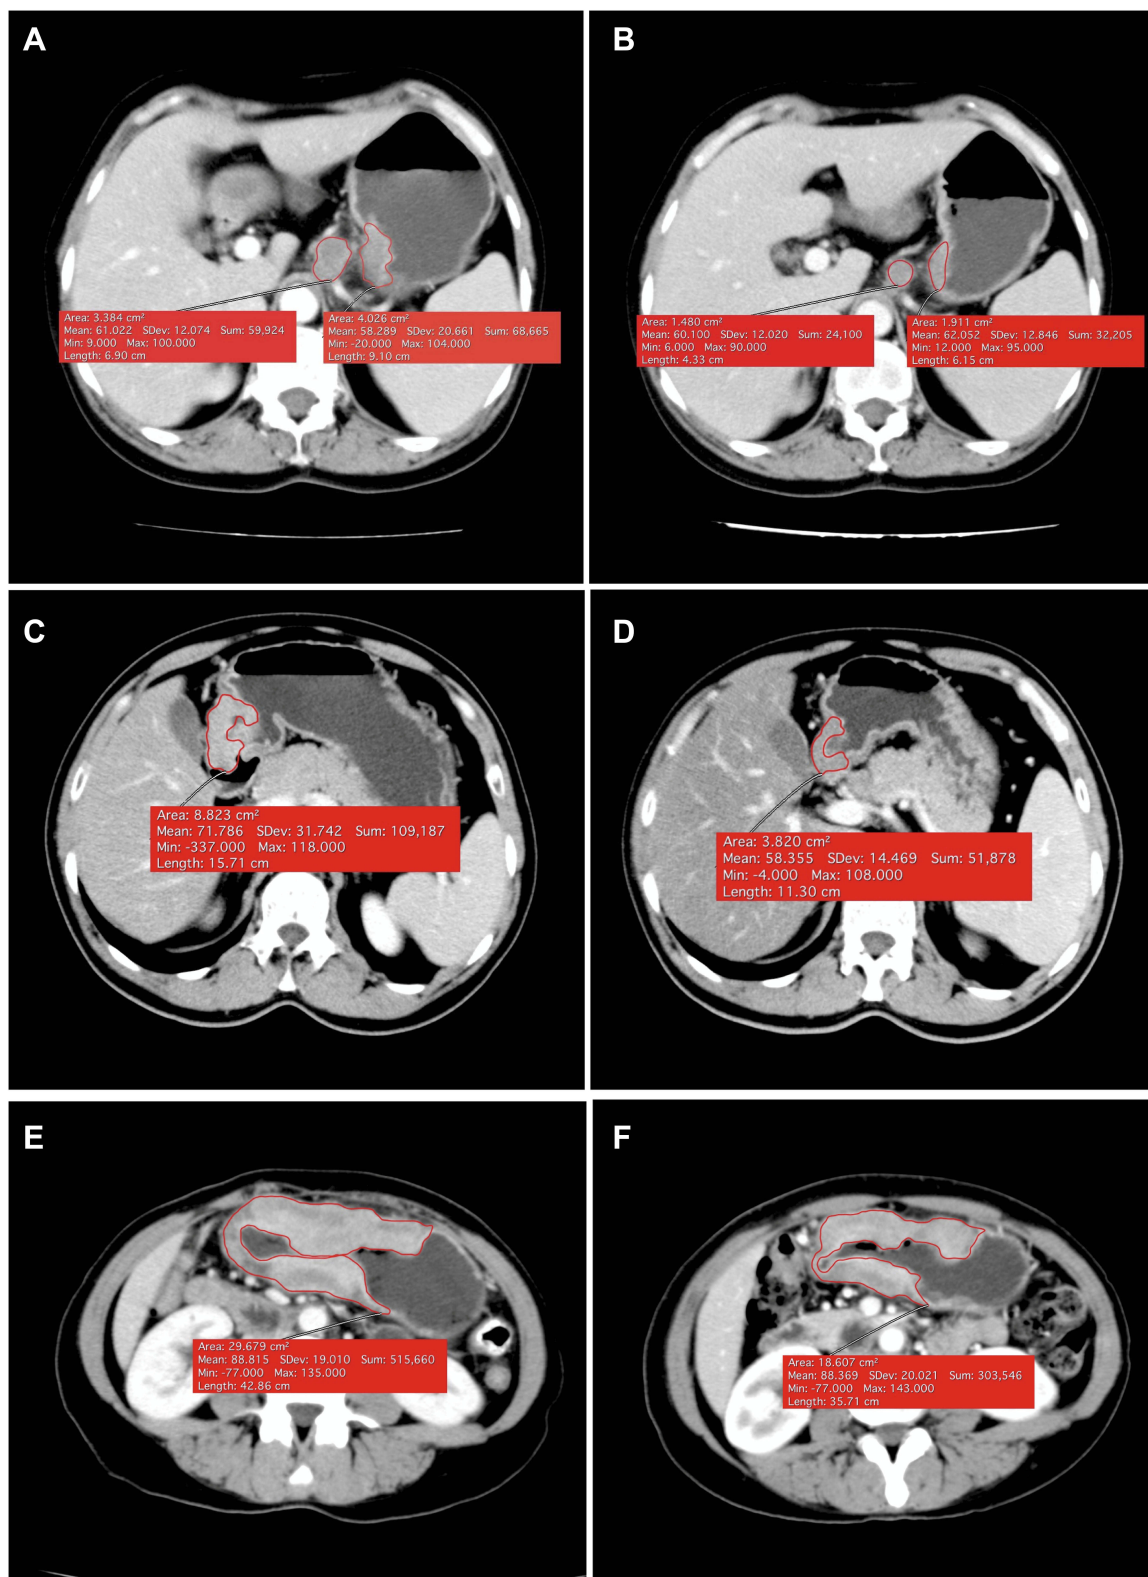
The CT volume measurement of the primary lesions and lymph node before and after neoadjuvant chemotherapy (NAC). Case 1: the total volume was 25.3 cm³ (primary lesion 21.1 cm³, the index lymph node 4.2 cm³) before chemotherapy (A), and decreased to 15.0 cm³ (B) after NAC (primary lesion 13.1 cm³, the index lymph node 1.9 cm³), the percentage volume reduction rate (VRR) was 40.7%. Case 2: the total volume was 68.6 cm³ before chemotherapy (C), and decreased to 20.8 cm³ (D) after NAC, the VRR was 69.7%. Case 3: the total volume was 171.9 cm³ before chemotherapy (E), and decreased to 101.6 cm³ (F) after NAC, the VRR was 40.9%.
